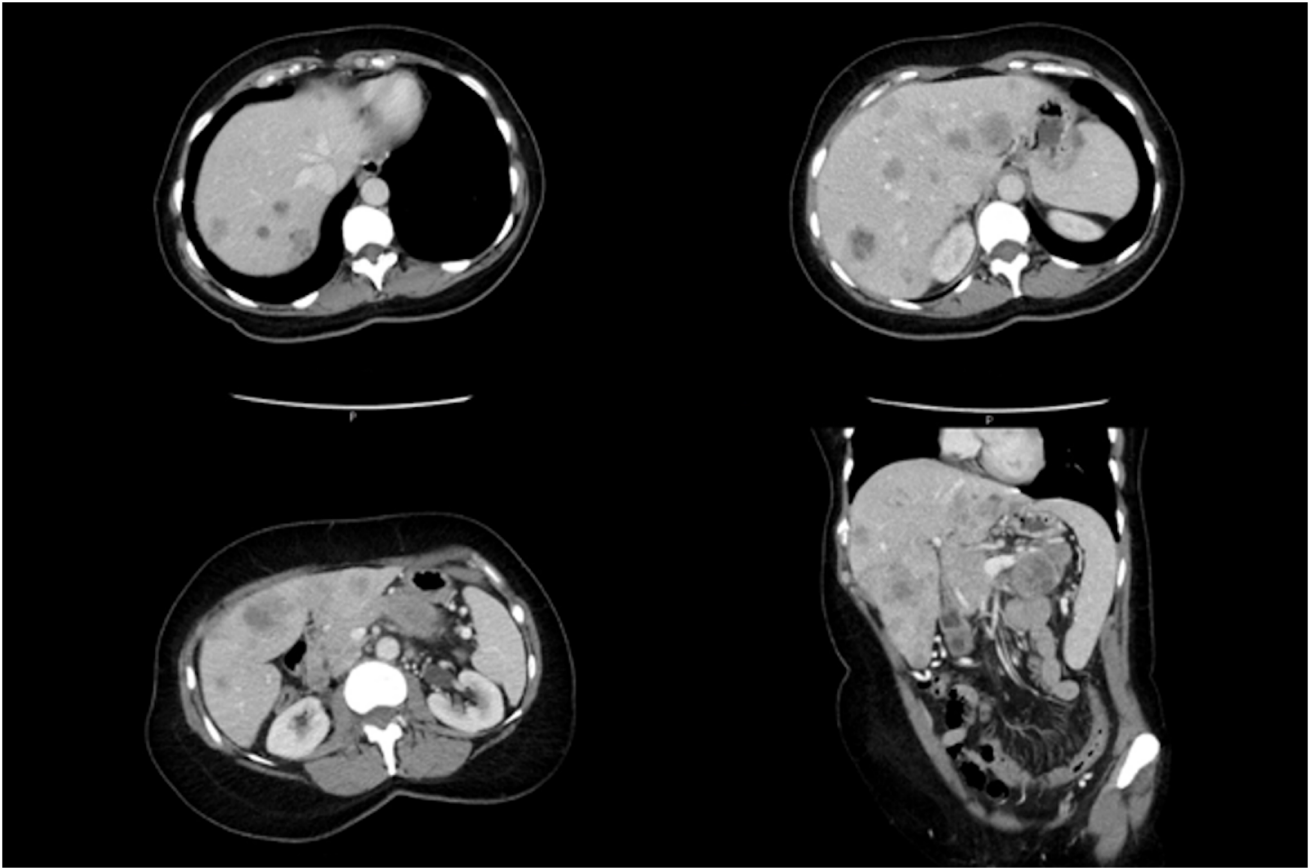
CT at presentation (September 2018) showing multiple hepatic lesions consistent with metastases.
